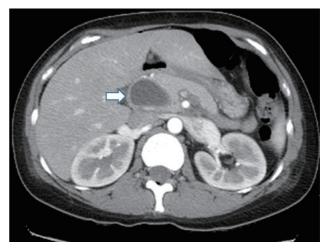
Abdominal CT showed a choledochal cyst (white arrow) without intrahepatic bile duct dilation.
